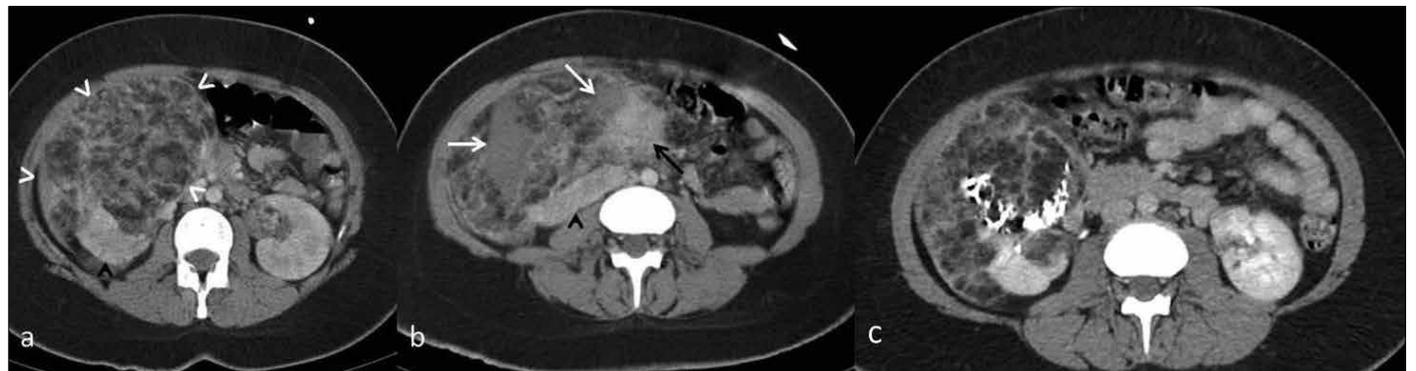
a-c. Axial contrast-enhanced CT images show huge angiomyolipoma (white arrowheads) with large fatty components (a), hyperdense acute (white arrows) and isodense former (black arrow) hemorrhagic areas and the right kidney parenchyma (black arrowheads) displaced inferior and medial by mass (b), and significant reduction (59%) in size of mass 5 months after embolization (c)
